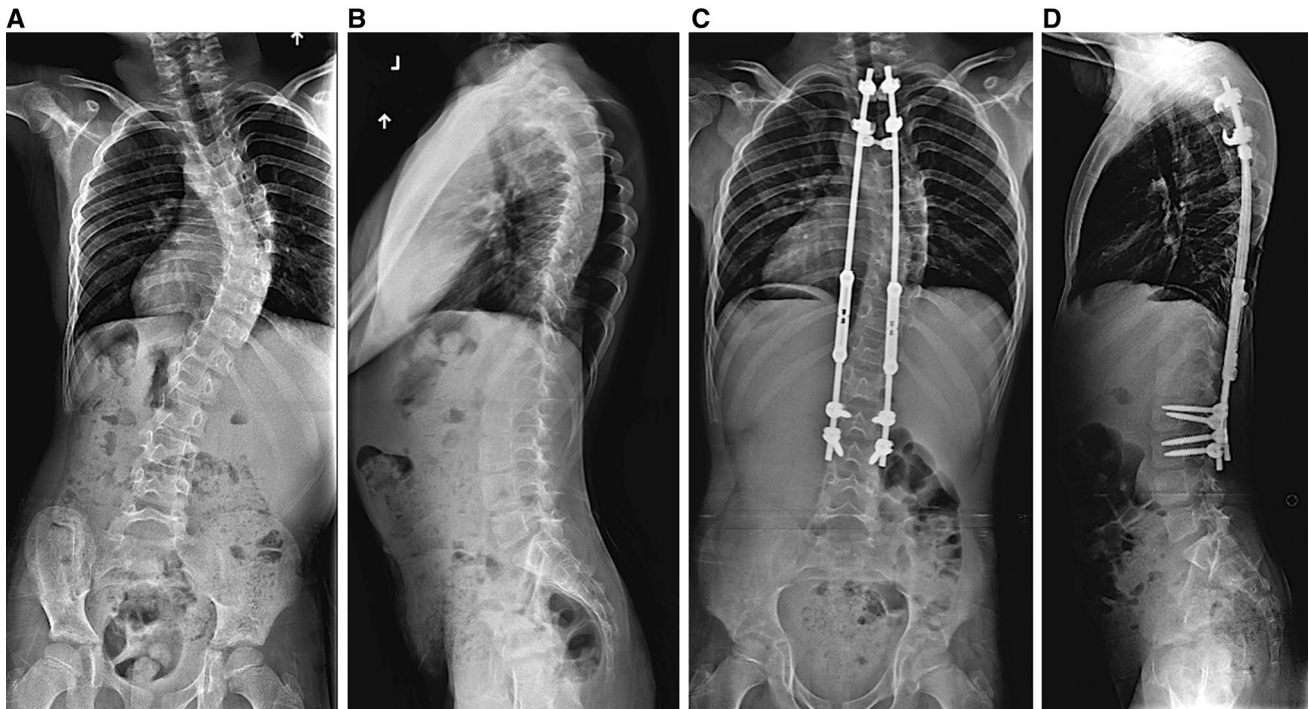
Radiograph of instrumentation and deformity correction with dual growing rods. Preoperative anteroposterior (a) and lateral (b) radiographs and postoperative anteroposterior (c) and lateral (d) radiographs of an early-onset scoliosis (EOS) patient are shown
